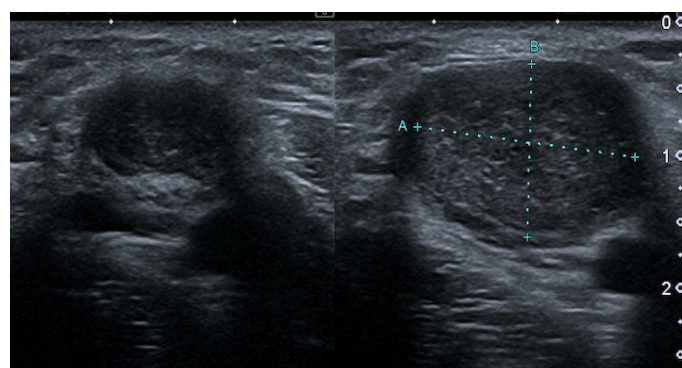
Sonographic appearance of axillary mass, this is the imaging of our patient at the first examination.
